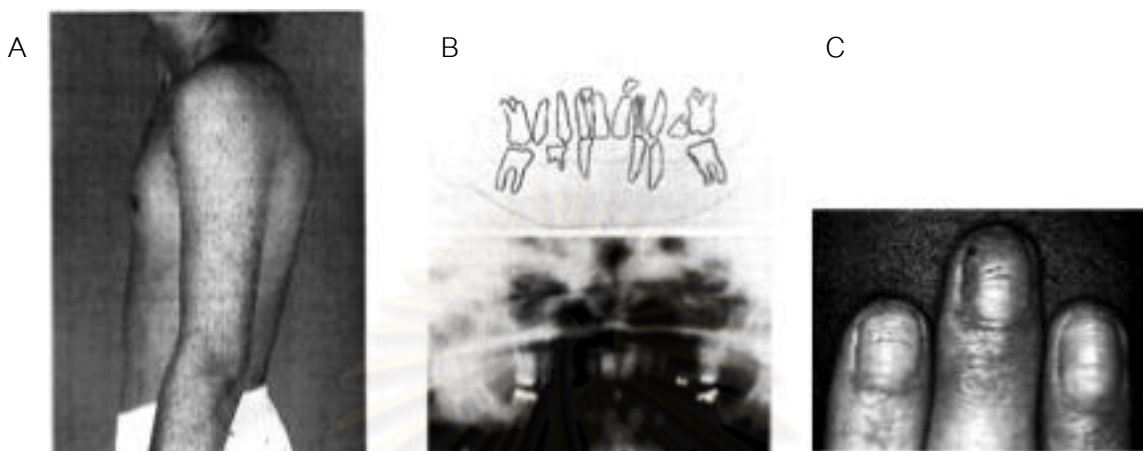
Clinical manifestation of the patient from Netherlands with AREDYLD (6) (A) Bilateral amastia. (B) X-ray of the upper and lower jaws. (C) Nails of the propoita showing transverse as well as longitudinal grooves (6).
